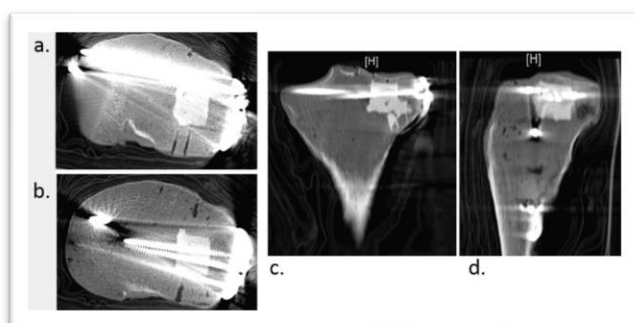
CT-Scan showing distribution of Norian calcium phosphate in the completed tibial plateau fixation construct: a and b. Axial scan superior to inferior, c. Coronal scan, d. Sagittal scan.
